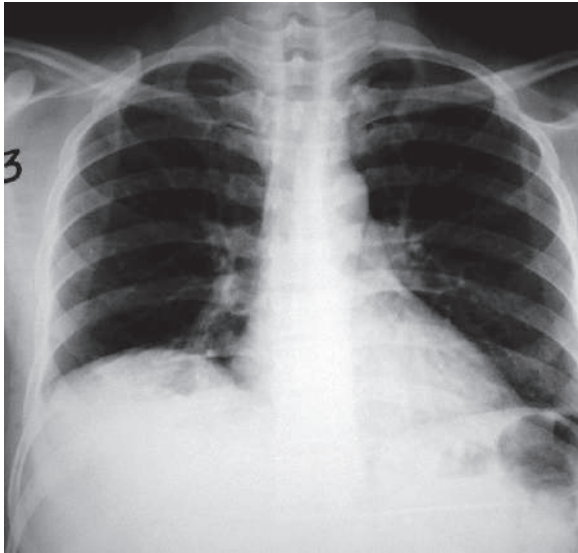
A plain chest radiograph shows a raised right diaphragm due to hepatic abscess
